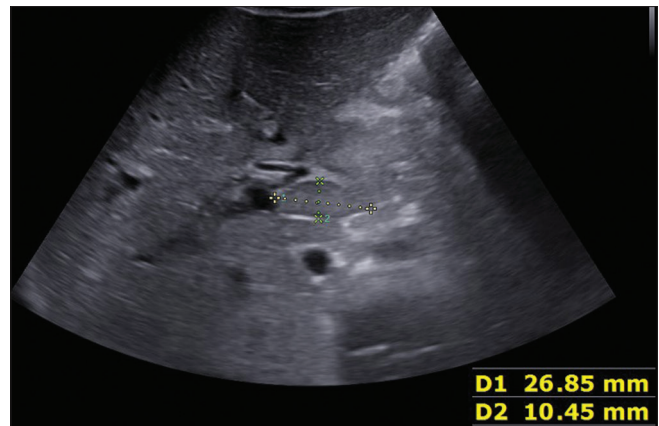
A 5-year-old male with acute hepatitis A. Longitudinal ultrasound view of liver shows porta-hepatis lymphadenopathy
